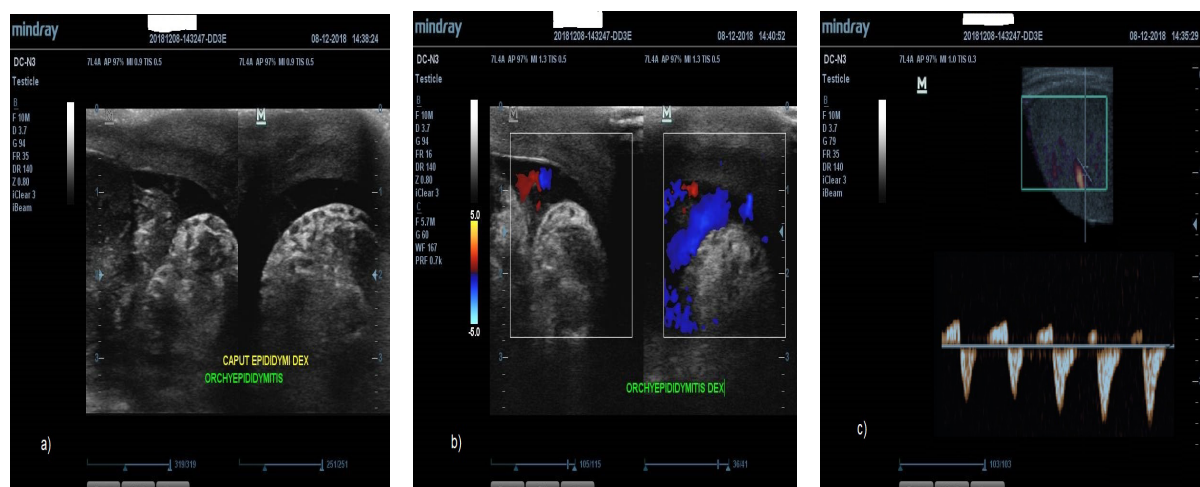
a) Ultrasonography of the right testis demonstrates an edema of the right epididymis; b) Color Power Doppler shows slightly increased blood flow in the right testis; c) Spectral Doppler demonstrates a reversal of diastolic flow.
